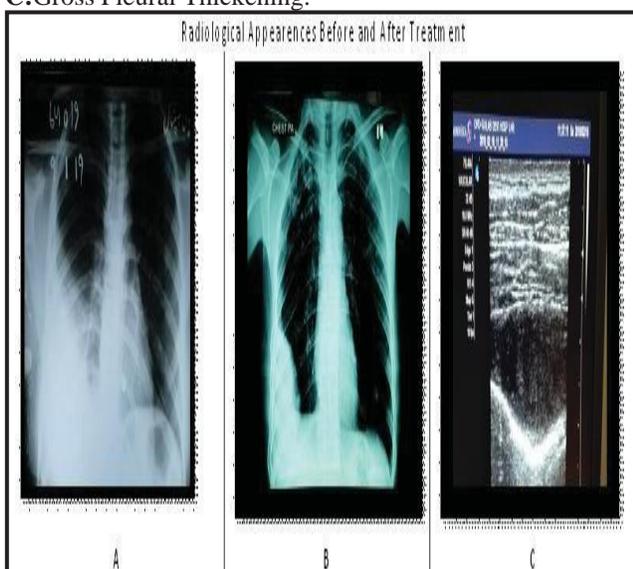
Radiographical Appearance Before & After Treatment.
